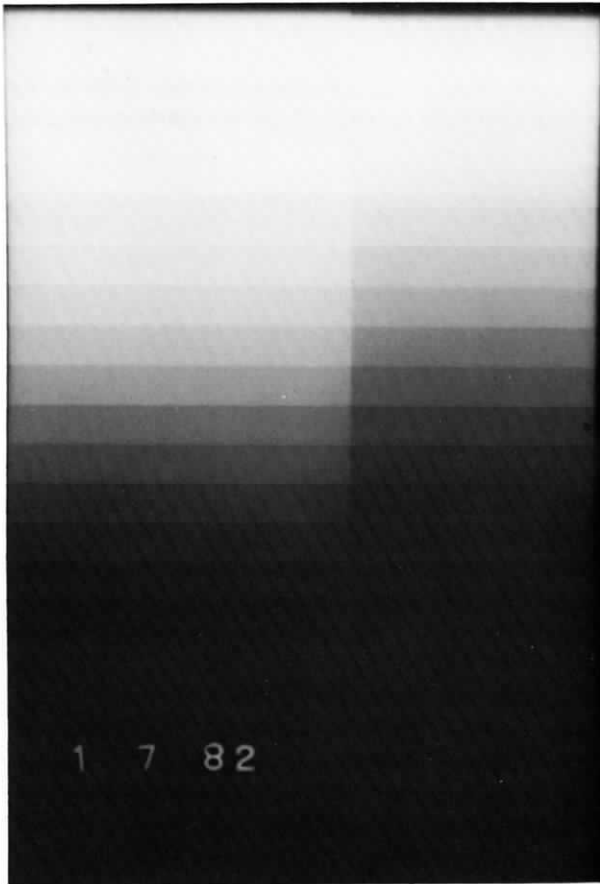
Effect of fog on radiographic film. One half of the step wedge image (screen-film exposure) was exposed to safelights for 4 minutes. It is apparent that the fog is not perceptible in the unexposed portion of the image nor is it apparent in the dense portions of the film. Fog tests carried out with unexposed film will not indicate the true effect of fog in the mid-densities, the region of primary importance in radiology. Also, in visually judging if the fog is excessive it is necessary to cover the line between the fogged and unfogged areas with a pencil. Eliminating the sharp border significantly changes your perception of the density difference between the two sides.
